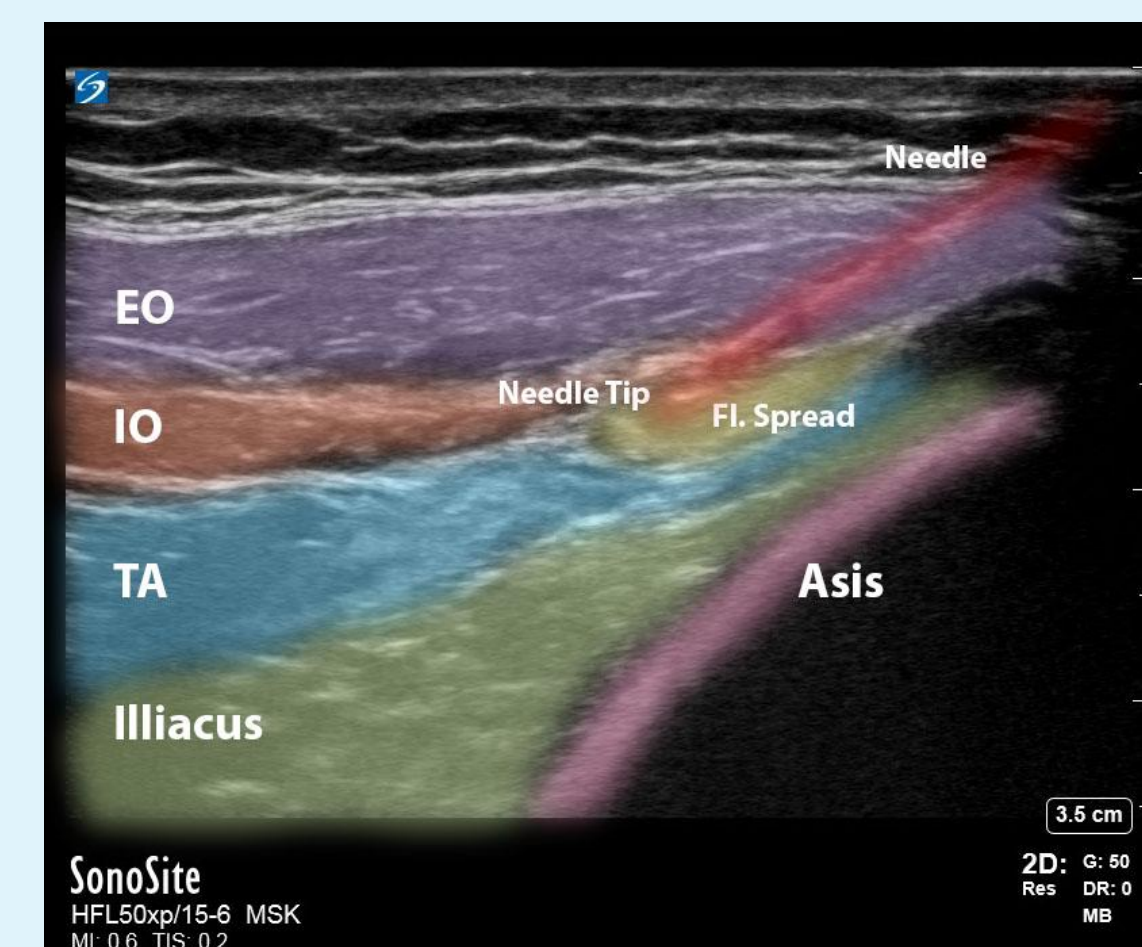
(left) Post-injection ilioinguinal block ultrasound image; Figure 2b (right) same image with labels
